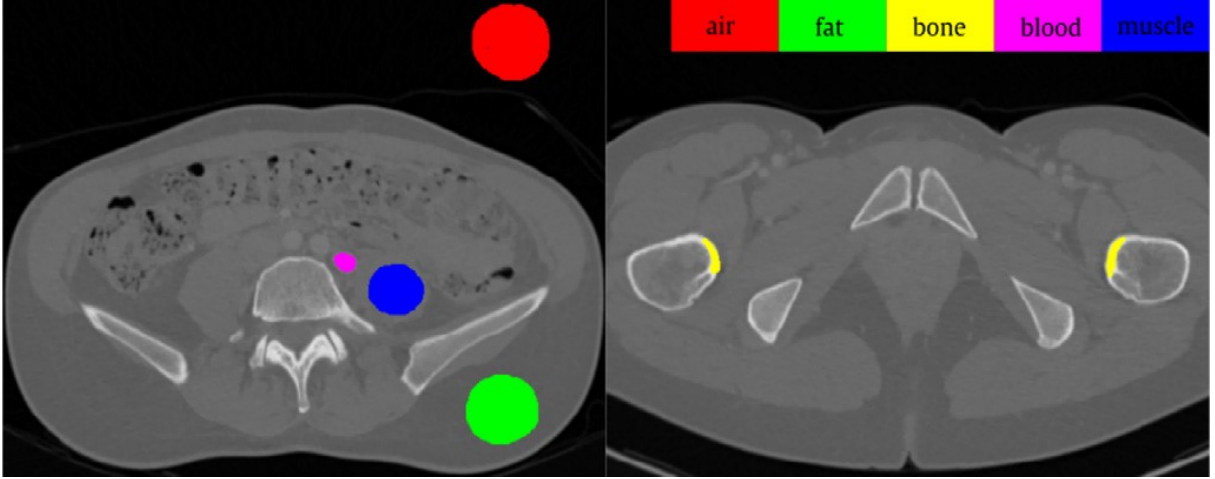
Example of CT slice where HU values of the considered tissues were selected for internal calibration. ROI content (mm^2): air: 1312; fat: 1109; bone: 160; blood: 92; muscle: 618. Mean HU (standard deviation): air: -1002 (7); fat: -90 (12); bone: 1233 (236); blood: 217 (16); muscle: 60 (12).
